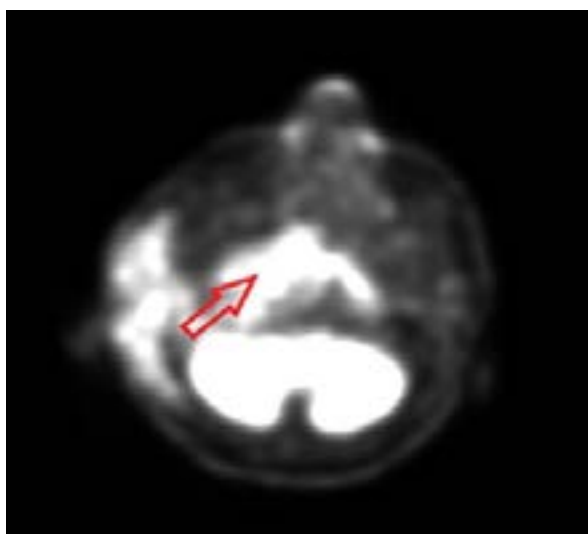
PET-CT scan axial section indicated a mass lesion at the skull base, involving bilateral nasopharynx (indicated by red arrow).
